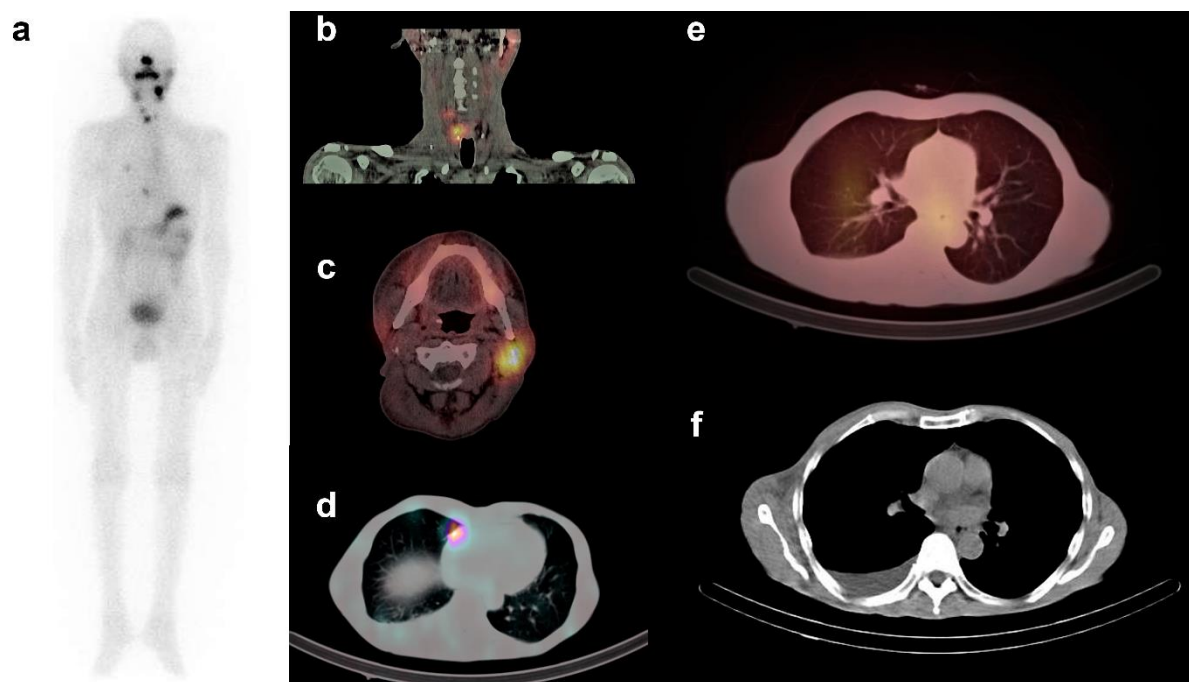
a. Whole body ^{131}I scan showed post-surgical thyroid remnant (PSTR) in the right thyroid lobe with right cervical, lung and pericardial metastasis. b. SPECT/CT confirmed PSTR and cervical lymphnode metastasis. c. Asymmetric iodine uptake in the left parotid gland is due to the previous right parotidectomy. d. Pericardial metastasis. e. Metastatic pulmonary nodule. f. Right sided pleural effusion.
